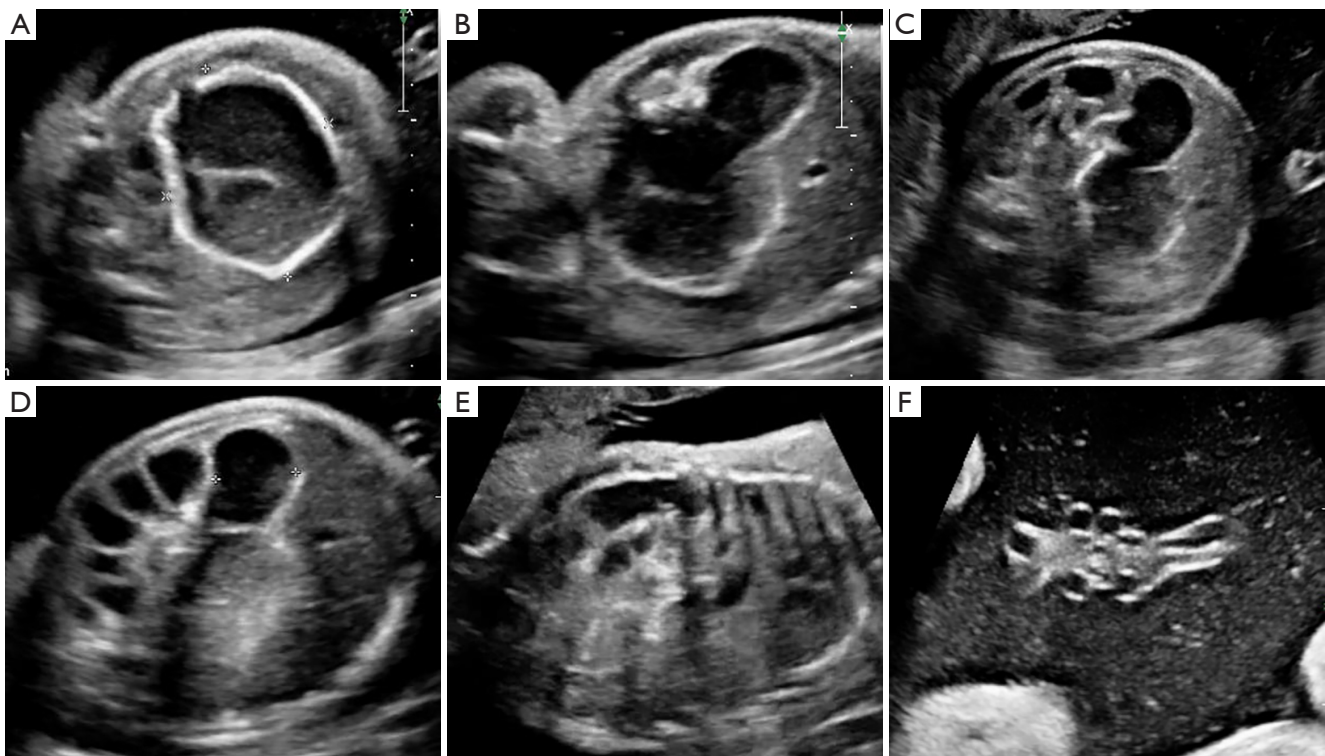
Ultrasound features at 32 weeks of gestation. Ultrasound features at 32 weeks of gestation. (A,B) show the significantly enlarged intestine and the thickened intestinal wall. (C,D) show this segment of intestine communicating with the surrounding intestine. (E) shows the appearance of the “coffee bean” sign. (F) shows the middle of the umbilical cord rotated twice.
